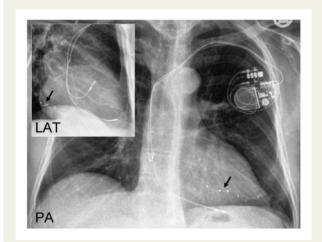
Chest X-ray after CRT-P implantation. Stable lead position in the right atrium, the right ventricular apex and a lateral vein of the coronary sinus. No evidence for pneumothorax. LAT, lateral view; PA, posterior-anterior view.
